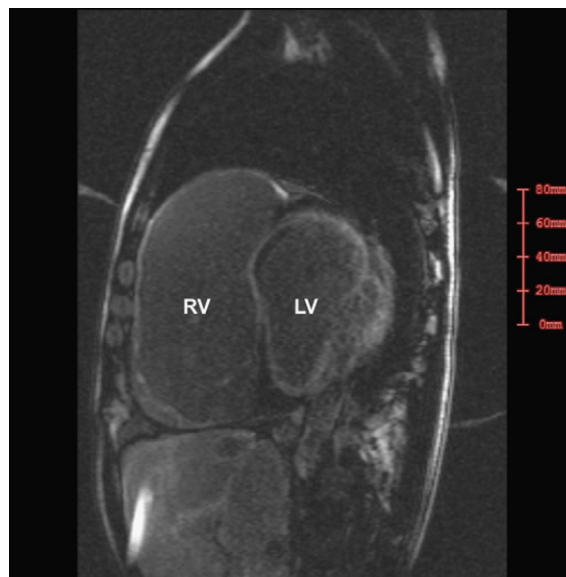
Delayed gadolinium-enhanced MRI demonstrating delayed enhancement of biventricles and significant right ventricular enlargement. LV, left ventricle; RV, right ventricle.
